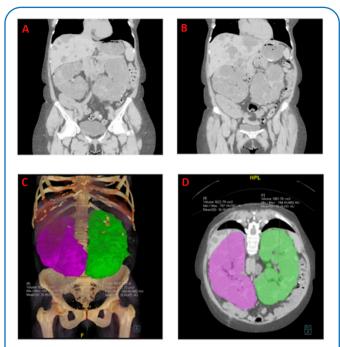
Computed tomography. A: Coronal view of native kidneys; B: Coronal view of native kidneys; C: Reconstruction of both polycystic kidneys; D: Crosssectional view with volume of both kidneys.
